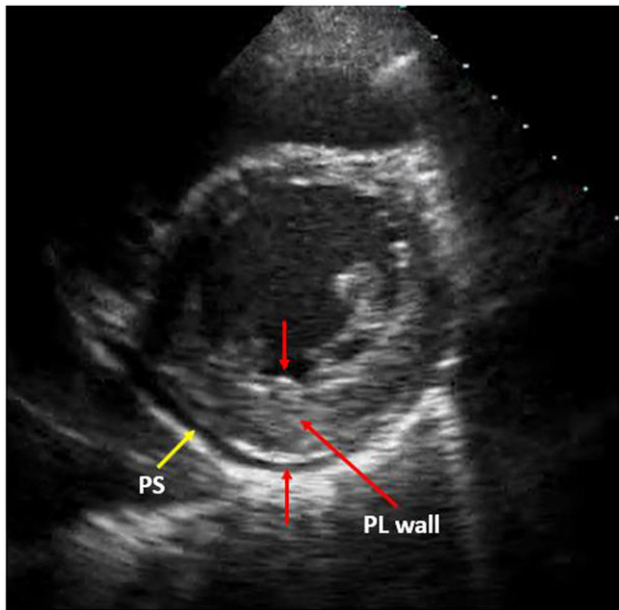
Echocardiographic image on presentation of the left ventricular base in the parasternal short-axis plane showing thickening of the posterolateral (PL) wall (red arrows). PS = Pericardial space.
